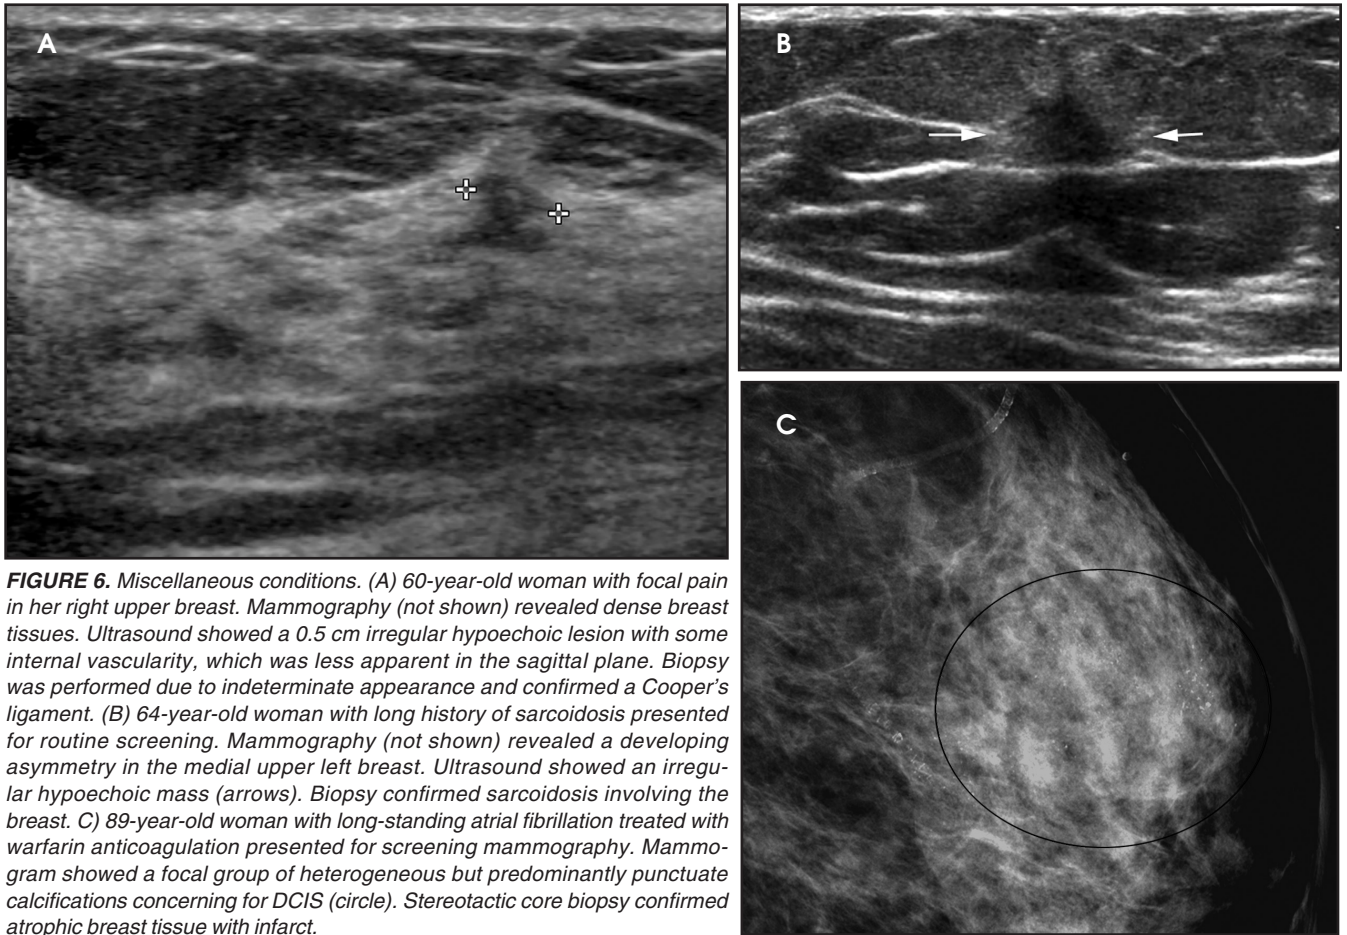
Miscellaneous conditions. (A) 60-year-old woman with focal pain in her right upper breast. Mammography (not shown) revealed dense breast tissues. Ultrasound showed a 0.5 cm irregular hypoechoic lesion with some internal vascularity, which was less apparent in the sagittal plane. Biopsy was performed due to indeterminate appearance and confirmed a Cooper's ligament. (B) 64-year-old woman with long history of sarcoidosis presented for routine screening. Mammography (not shown) revealed a developing asymmetry in the medial upper left breast. Ultrasound showed an irregular hypoechoic mass (arrows). Biopsy confirmed sarcoidosis involving the breast. (C) 89-year-old woman with long-standing atrial fibrillation treated with warfarin anticoagulation presented for screening mammography. Mammogram showed a focal group of heterogeneous but predominantly punctate calcifications concerning for DCIS (circle). Stereotactic core biopsy confirmed atrophic breast tissue with infarct.
